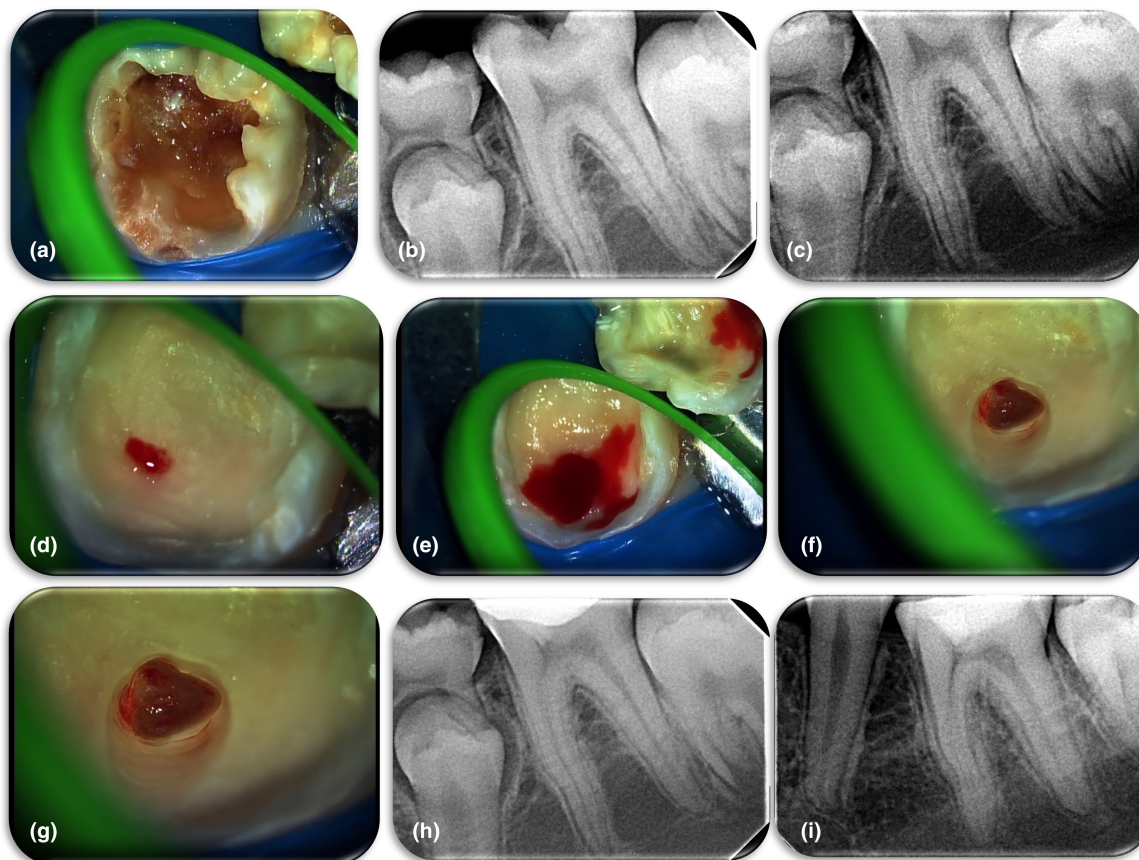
(a) Clinical figure of a deep caries in a left mature first mandibular molar of a 14-year-old patient after tooth isolation, (b, c) initial radiographs of the tooth for the evaluation of caries depth and the condition of periapical tissues, the patient take analgesics due to spontaneous pain and clinically the tooth presents pain to percussion, (d) extravasation of blood serum fluid after communication with the pulp chamber following complete caries removal, (e) excessive bleeding after the first cut of pulp tissue, (f, g) clinical appearance of the pulp tissue after control of bleeding (two different magnifications), (i) postoperative radiograph of the case with Total Fill BC in place over the coronal pulp tissue, (f) 24-month recall radiograph. Formation of a thick dentinal bridge is apparent.
